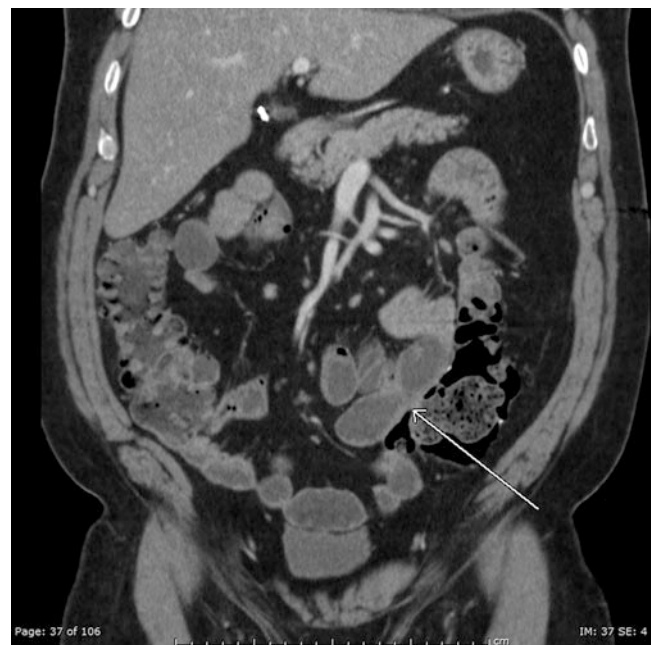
Coronal CT showing dilated and fluid filled small bowel in partial small bowel obstruction. Note non-dilated proximal small bowel and non-dilated distal small bowel
